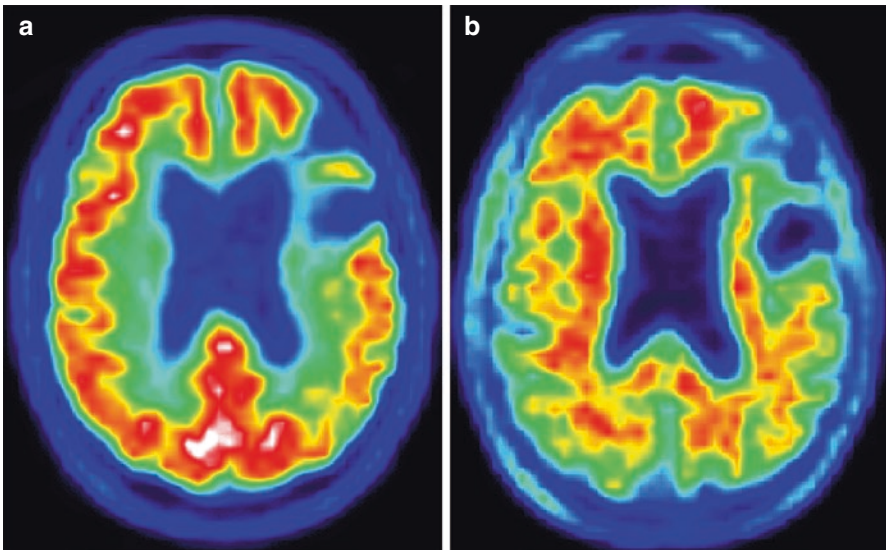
FDG PET (a) (left) in a patient with VaD and no AD as shown by negative amyloid imaging (b) (right)
